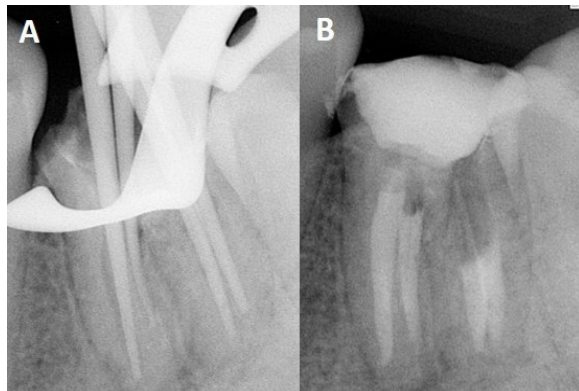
A. Try-in of the gutta-percha points; B. Final radiographic aspect after filling.
